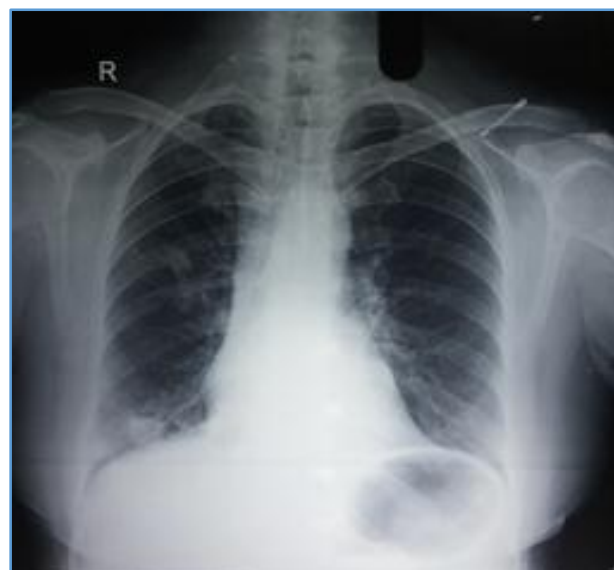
Chest X-Ray PA View after Treatment
